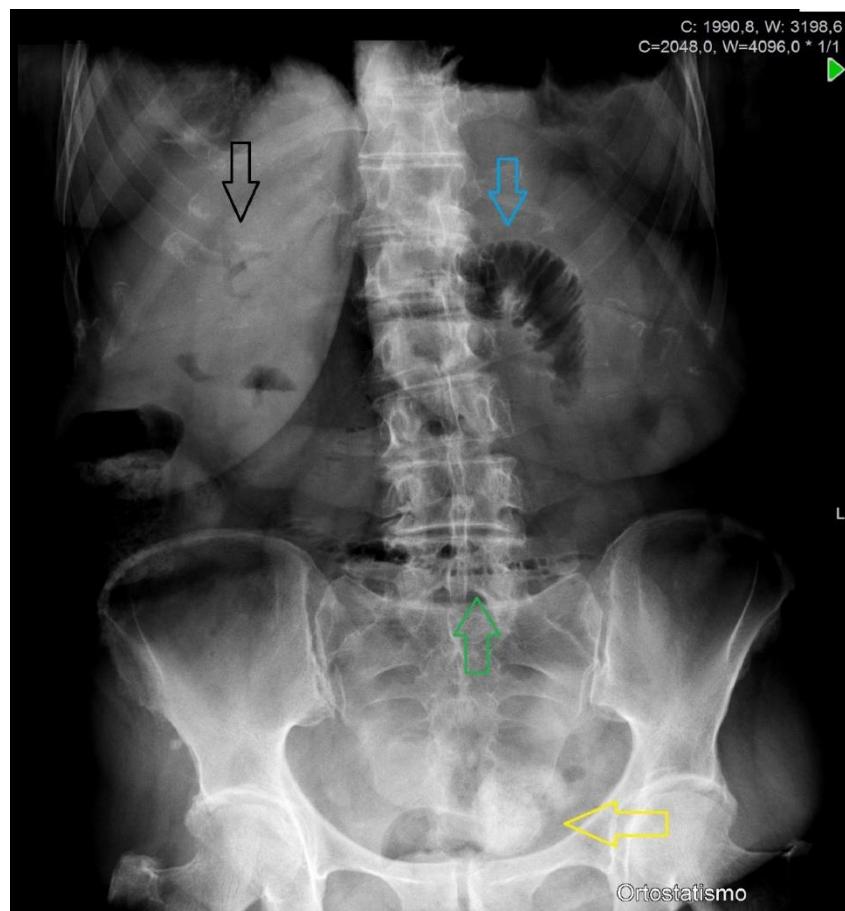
The plain abdominal radiograph demonstrated the Rigler's Triad: i) pneumobilia (black arrow); ii) a radio-paque gallstone located in the lower left abdominal quadrant (yellow arrow); iii) dilatation of small bowel loops. The presence of the "stretch" sign (blue arrow) and the "string of beads" sign (green arrow) were indicative of small bowel obstruction
